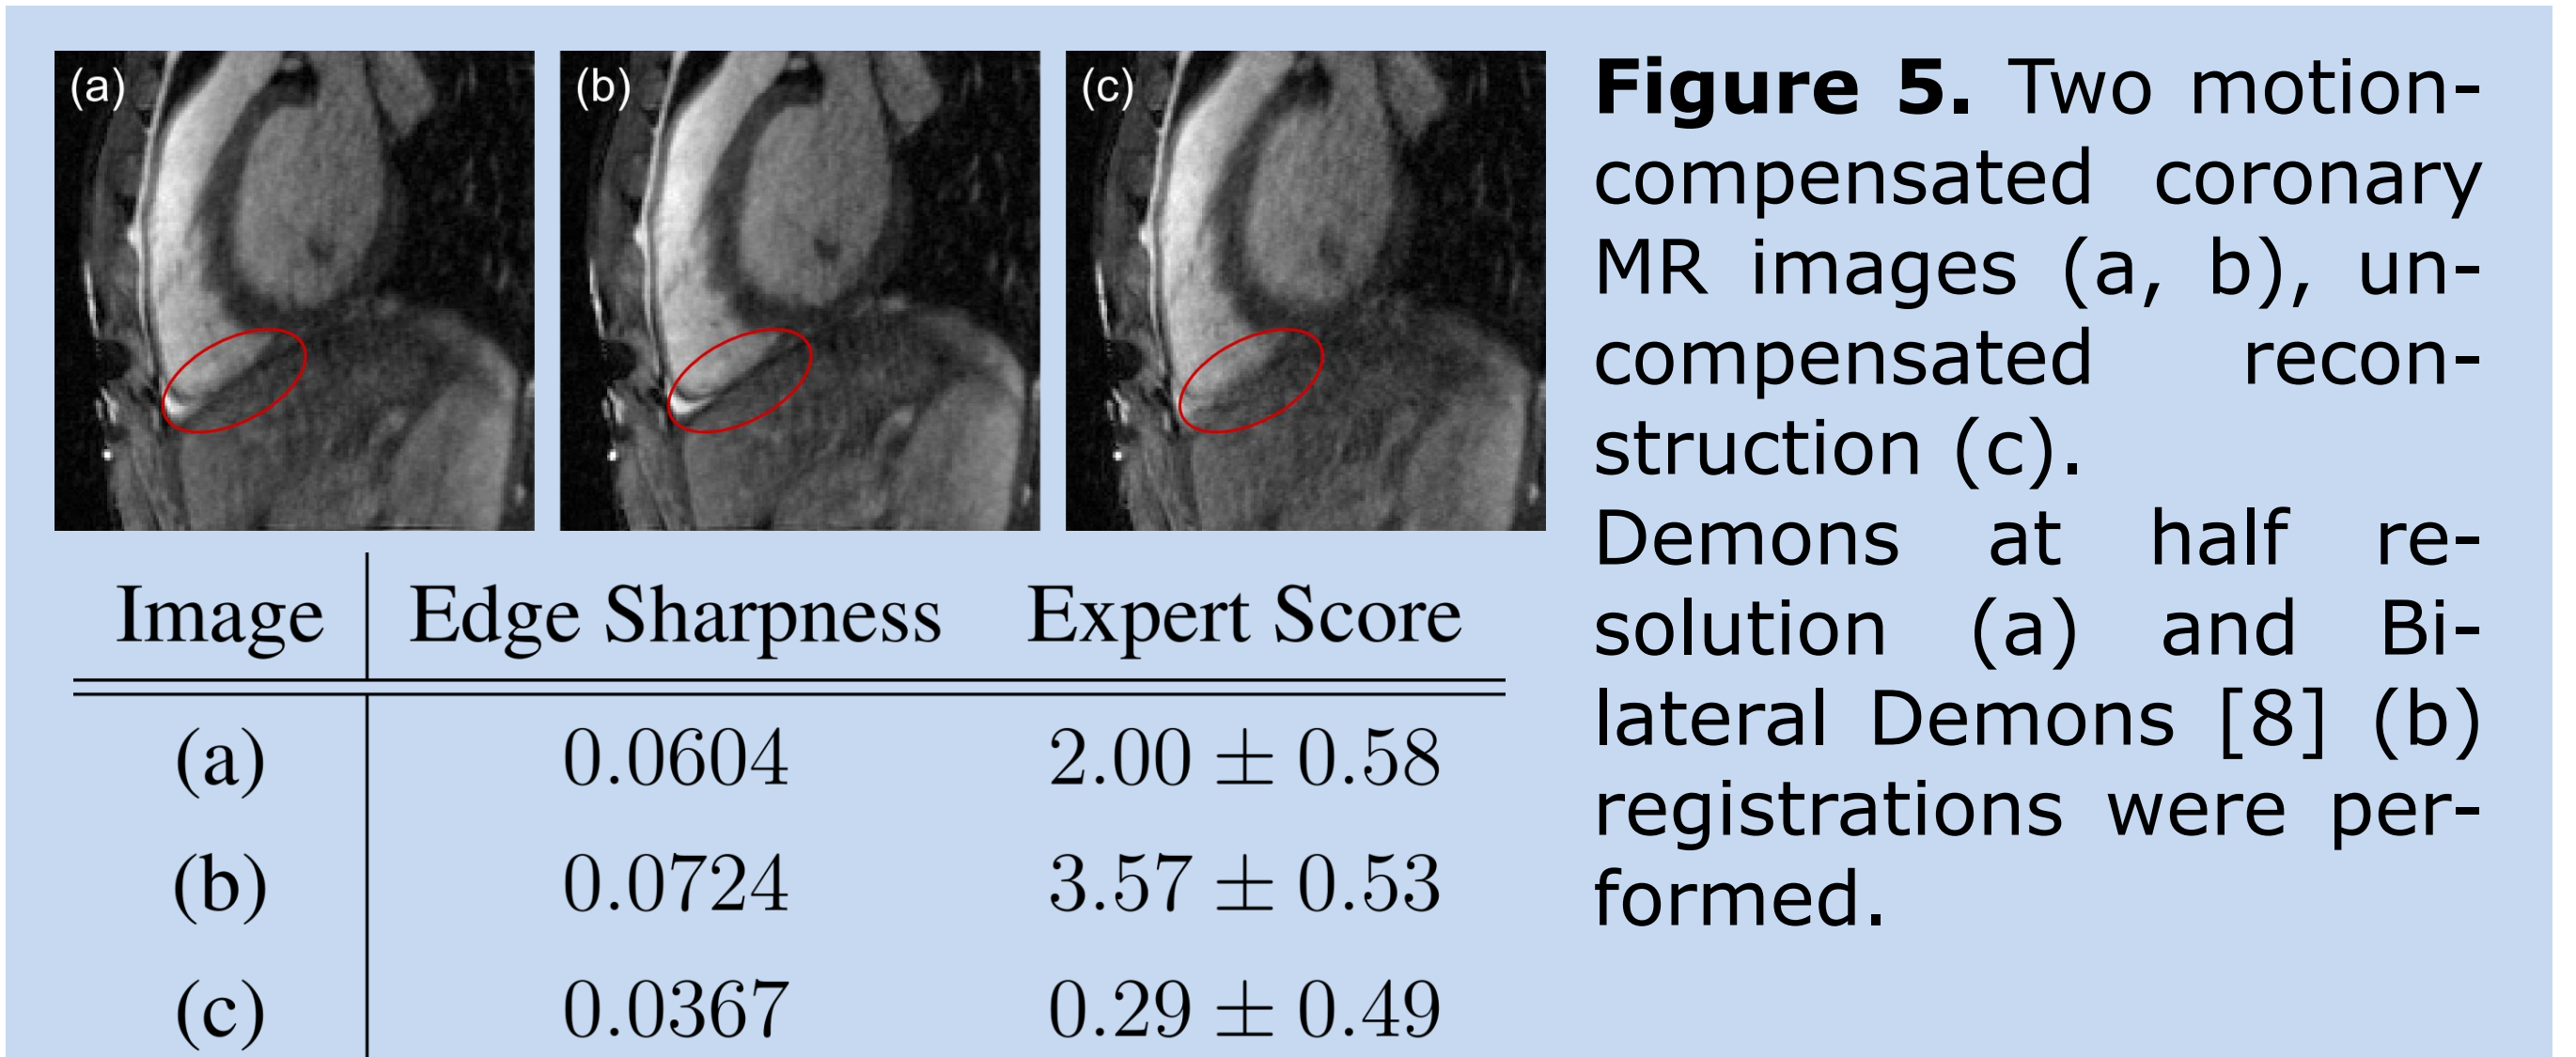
Two motion-compensated coronary MR images (a, b), uncompensated reconstruction (c). Demons at half resolution (a) and Bi-lateral Demons [8] (b) registrations were performed.
